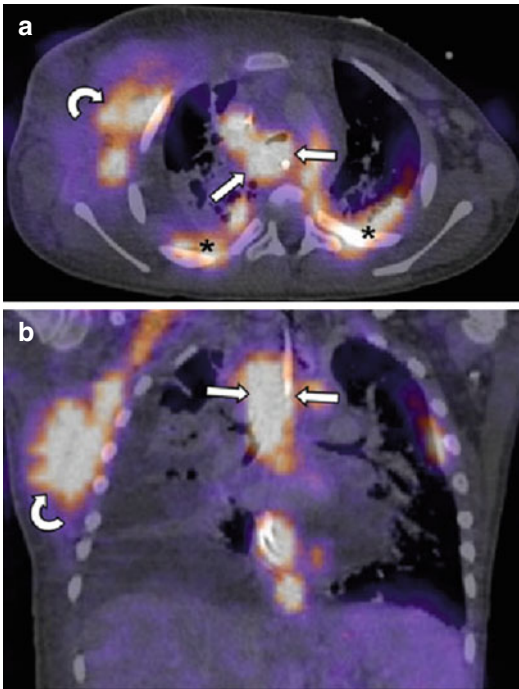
(a) sagittal, (b) coronal fused PET/CT imaging. Hypermetabolic activity is observed in soft tissue around the esophagus (*white arrows*), at multiple sites of the mediastinum, at the right axilla (*curved arrow*), as well as at pleural surfaces (*asterisks*)
